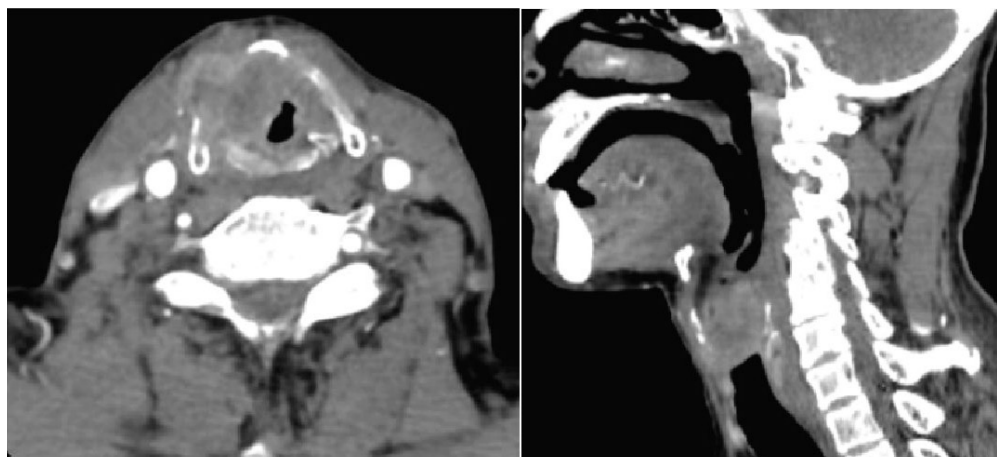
Male 72-year-old patient. Computed tomography in axial and sagittal plane showed the large tumor in the glottis invading the paraglottic space, thyroid cartilage and the infrahyoid muscles. Pathology showed squamous cell carcinoma
